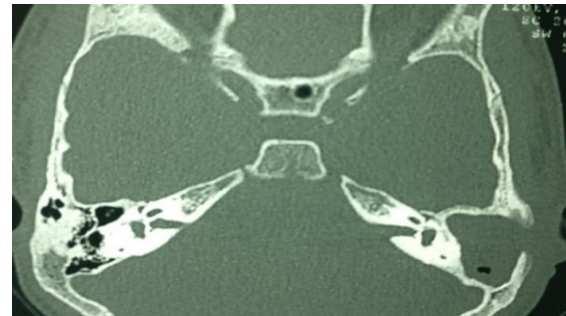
HRCT temporal bone axial section showing erosion of lateral wall of mastoid with soft tissue attenuating lesion in middle ear and mastoid.
